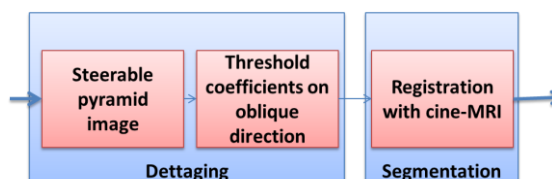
Block scheme for segmentation in t-MRI using the strategy proposed in [89].
